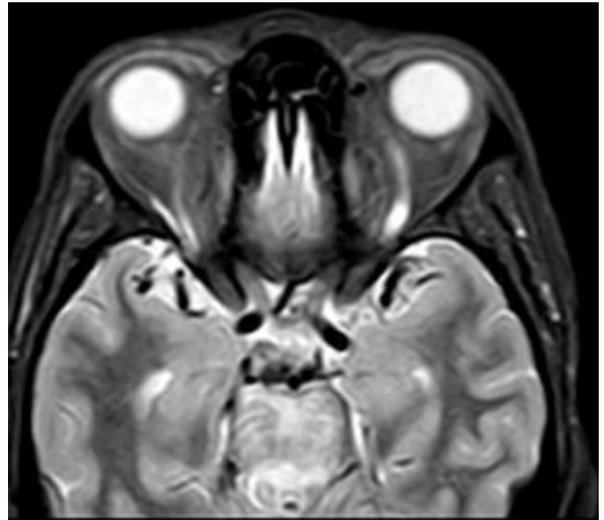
MRI showing, Axial FLAIR - Diffuse hyperintensity in Pons extending into middle cerebellar peduncle
